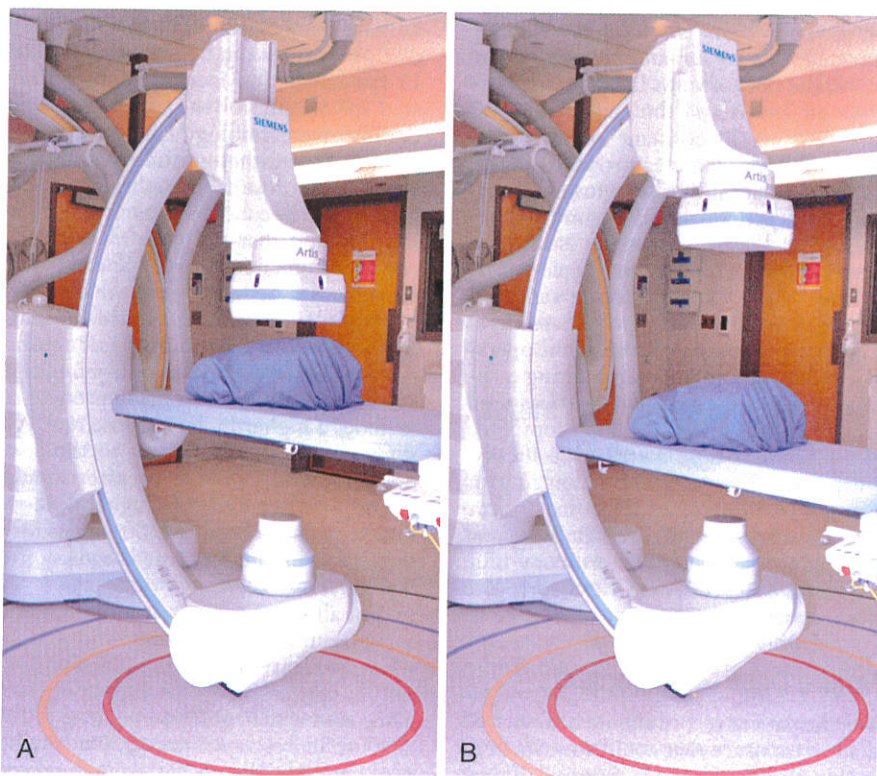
(A) Good imaging geometry with the table elevated and a small air gap (<10 cm). (B) Poor imaging geometry with a short distance between the x-ray tube and patient (table too low) and a great distance between the patient and image receptor (air gap). (Photographs courtesy Mayo Clinic, Rochester, MN.)
